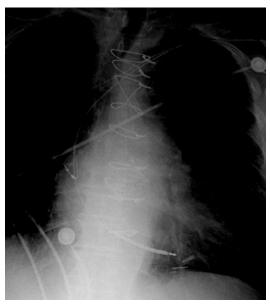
Chest radiograph with transcatheter heart valve in place
